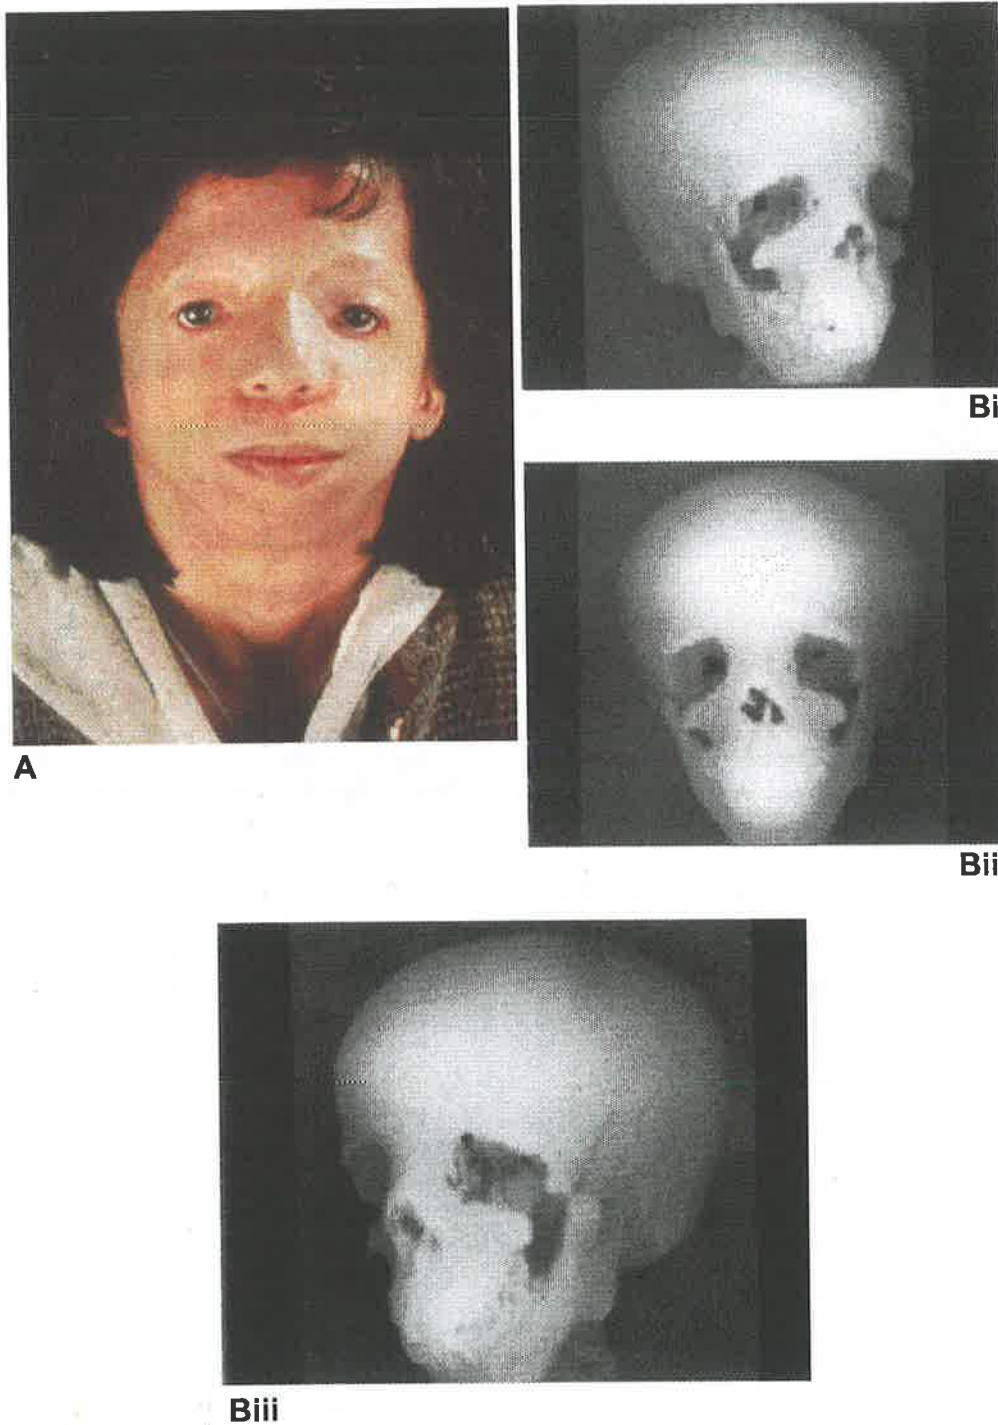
A. Twenty-nine-year-old Hong Kong Chinese woman with Treacher Collins syndrome (Tessier Number 6, 7, and 8 clefts). B. Three-dimensional CT reconstructions expose the true extent of the bony deficiency in the frontozygomatic region, the lateral orbital wall being formed by the hypoplastic greater wing of sphenoid (i-iii).*
